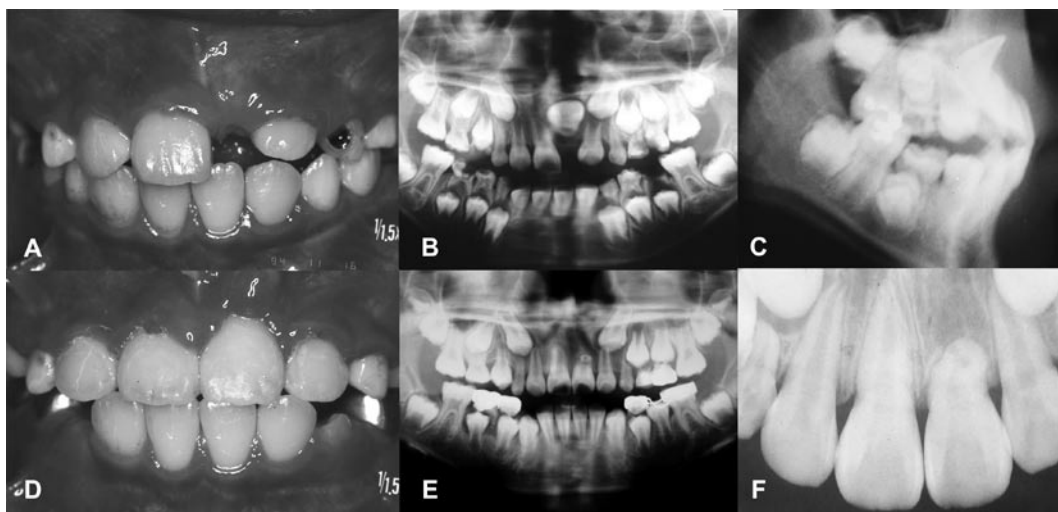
(A) Frontal view showing absence of left maxillary central incisor with space loss and midline deviation; (B) pretreatment panoramic radiograph of the root dilaceration; (C) pretreatment lateral cephalometric radiograph of the root dilaceration; (D) proper alignment of the left maxillary central incisor; (E) posttreatment panoramic radiograph of the root dilaceration; (F) posttreatment periapical radiograph of the root dilaceration.
